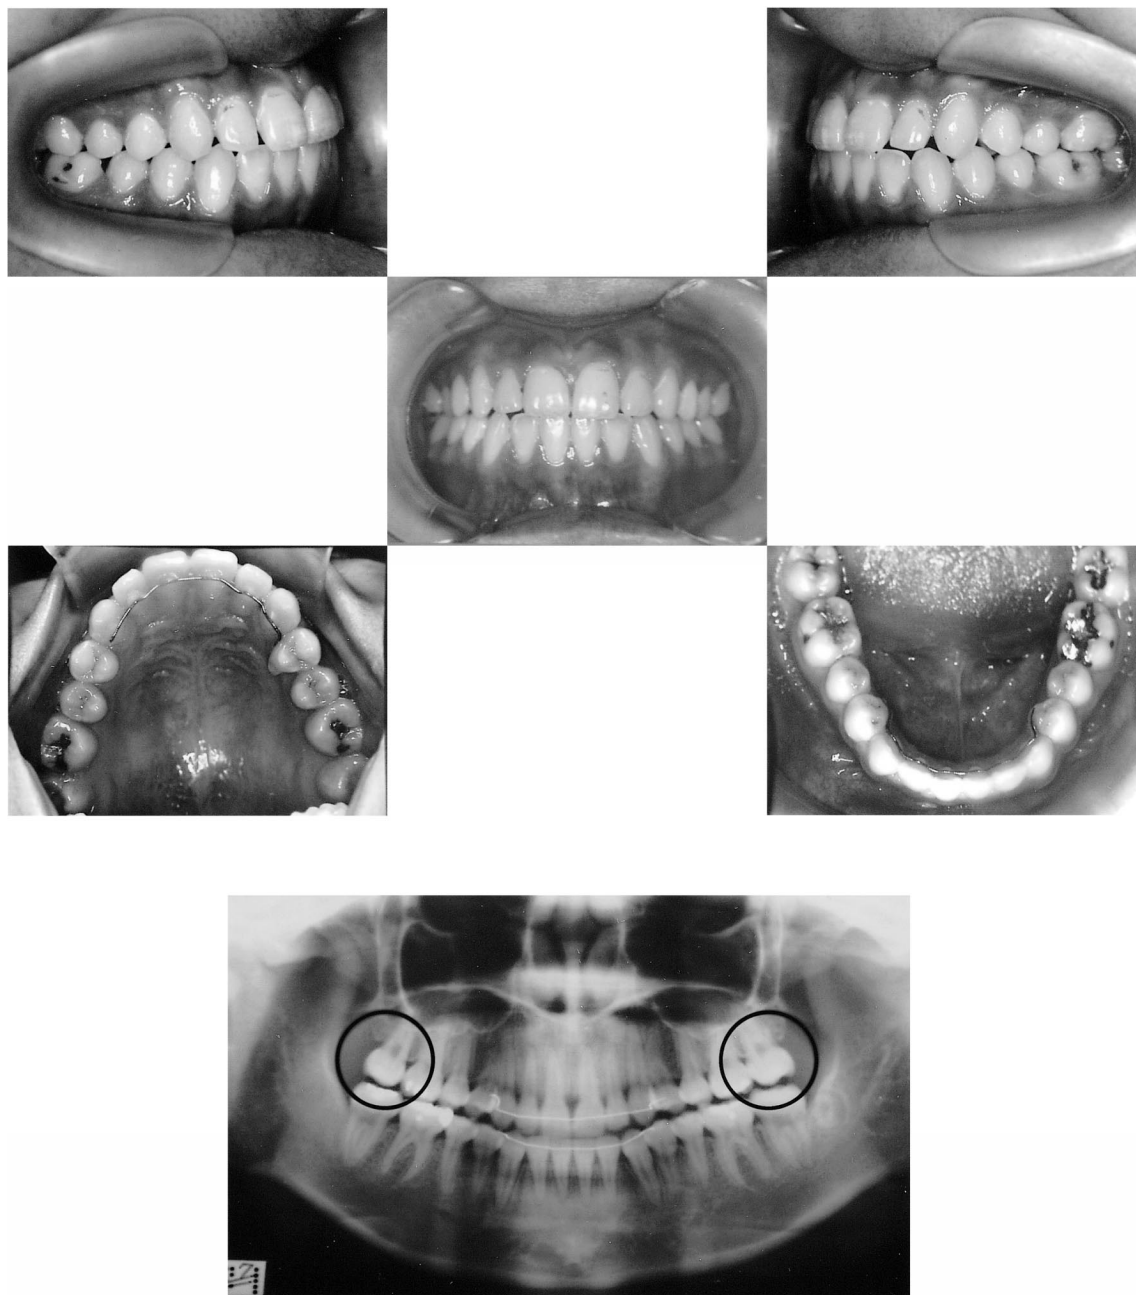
Photographs and panoramic X-ray film of the same case shown in Figure 7 taken at 12 years and 5 months of age.
